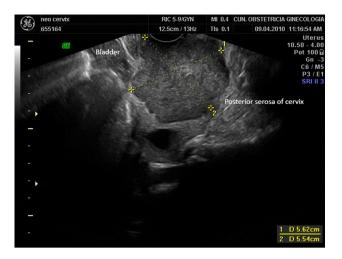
Transvaginal ultrasound showing a large cervical cancer in longitudinal plane. Deep stromal invasion is suspected. The limits of the lesion are close to cervical serosa
